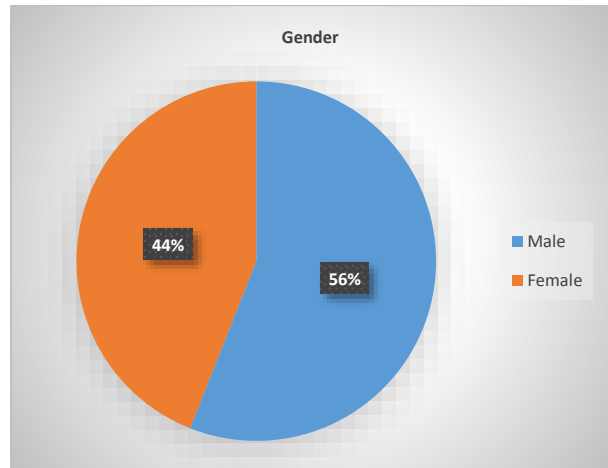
Gender distribution in patients with abnormal MRI findings.
